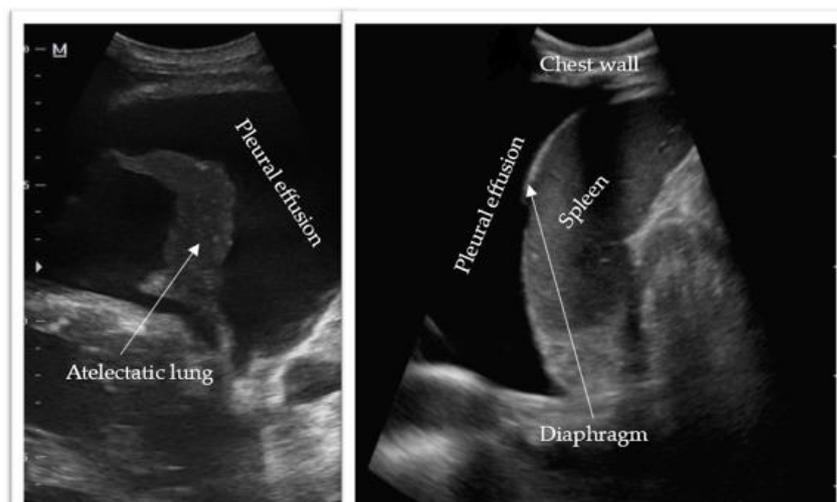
Thoracic ultrasonography demonstrating an anechoic pleural effusion with surrounding structures. Image (left) courtesy of Mohammad Osama Hussein Yonso, Radiopaedia.org, rID: 22793. Image (right) courtesy of Zhan Lim, Radiopaedia.org, rID: 94919.
